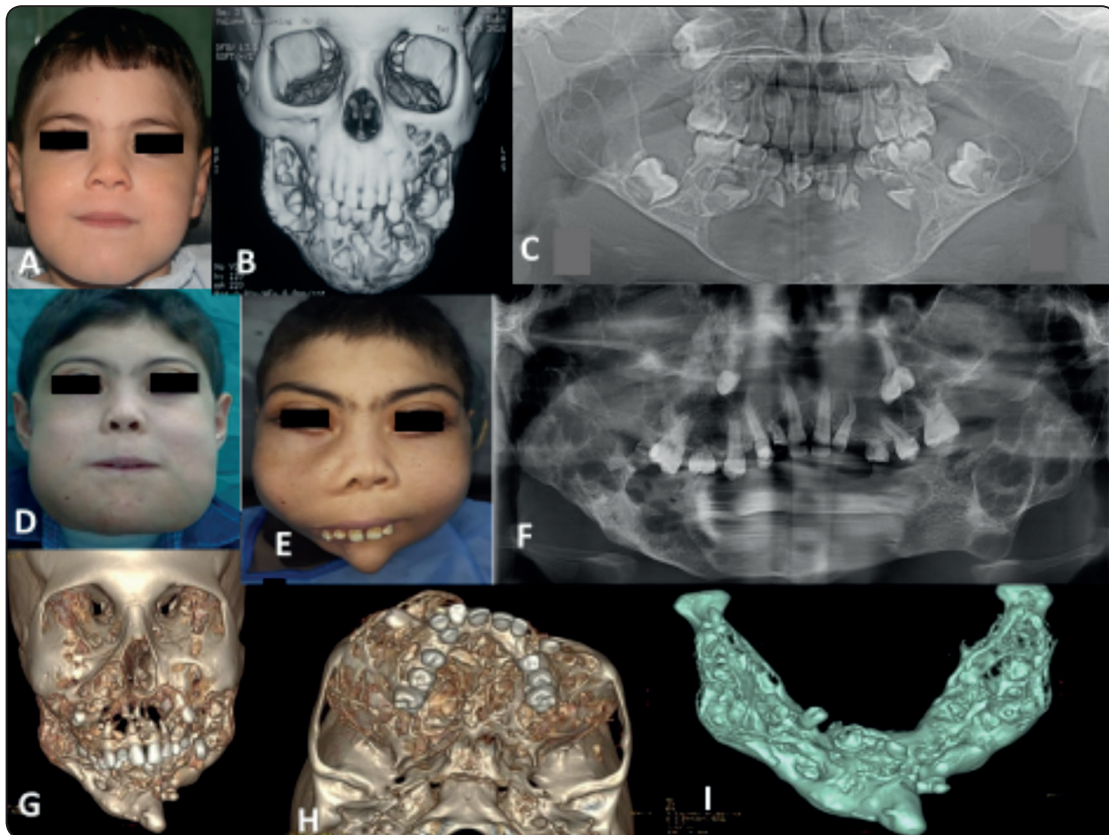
(A-I): (A) Clinical (B) Reconstructed 3D-CT (C) Panoramic views for (patient 1) at age 4 showing bilateral mandibular swelling, multilocular radiolucent lesions involving the entire mandible (sparing coronoids and condyles), and involving maxillary tuberosities and orbital floor. (D) Patient at age 10 showing large bilateral mandibular swelling before curettage of mandibular lesions, (E) Current clinical (F) Panoramic (G, H, I) Reconstructed 3D-CT views of the patient at 14 years showing a massive increase in maxillary expansion more in the right side, and involvement of coronoid processes.
